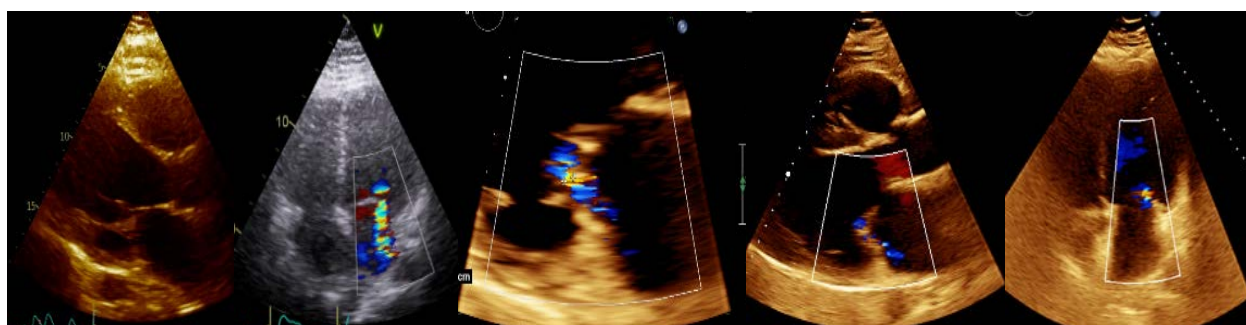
A: Parasternal long axis view and apical 4 chamber view showing moderate mitral regurgitation pre echo-guided CRT optimization. B: Parasternal short axis and apical 4 chamber view after echo-guided CRT optimization showing mild mitral regurgitation. Poor image qualities due to body habitus.
